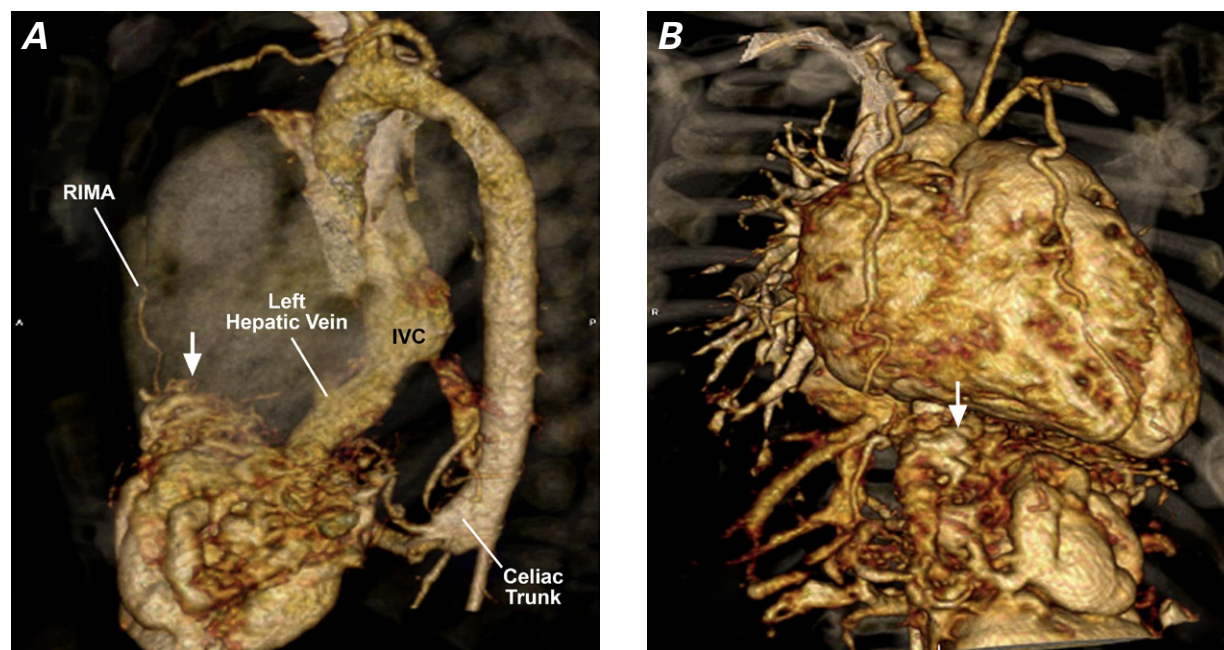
Computed tomograms (3-dimensional volume-rendered) in A) left lateral and B) anteroposterior views show a large, undefined (but well-circumscribed) vascular structure (arrows)—subdiaphragmatic and epigastric. The celiac trunk and right internal mammary artery (RIMA) supply this vascular structure. The left hepatic vein is prominent and appears to be draining the anomaly.
